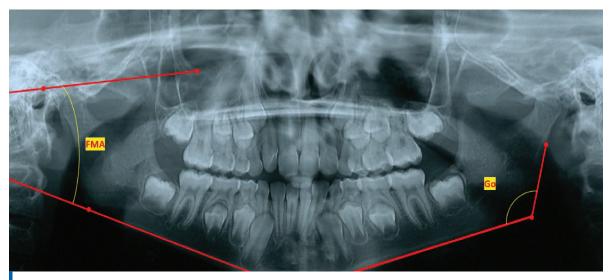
Gonial and Farnakfort mandibular plane angles shown on panoramic radiograph
